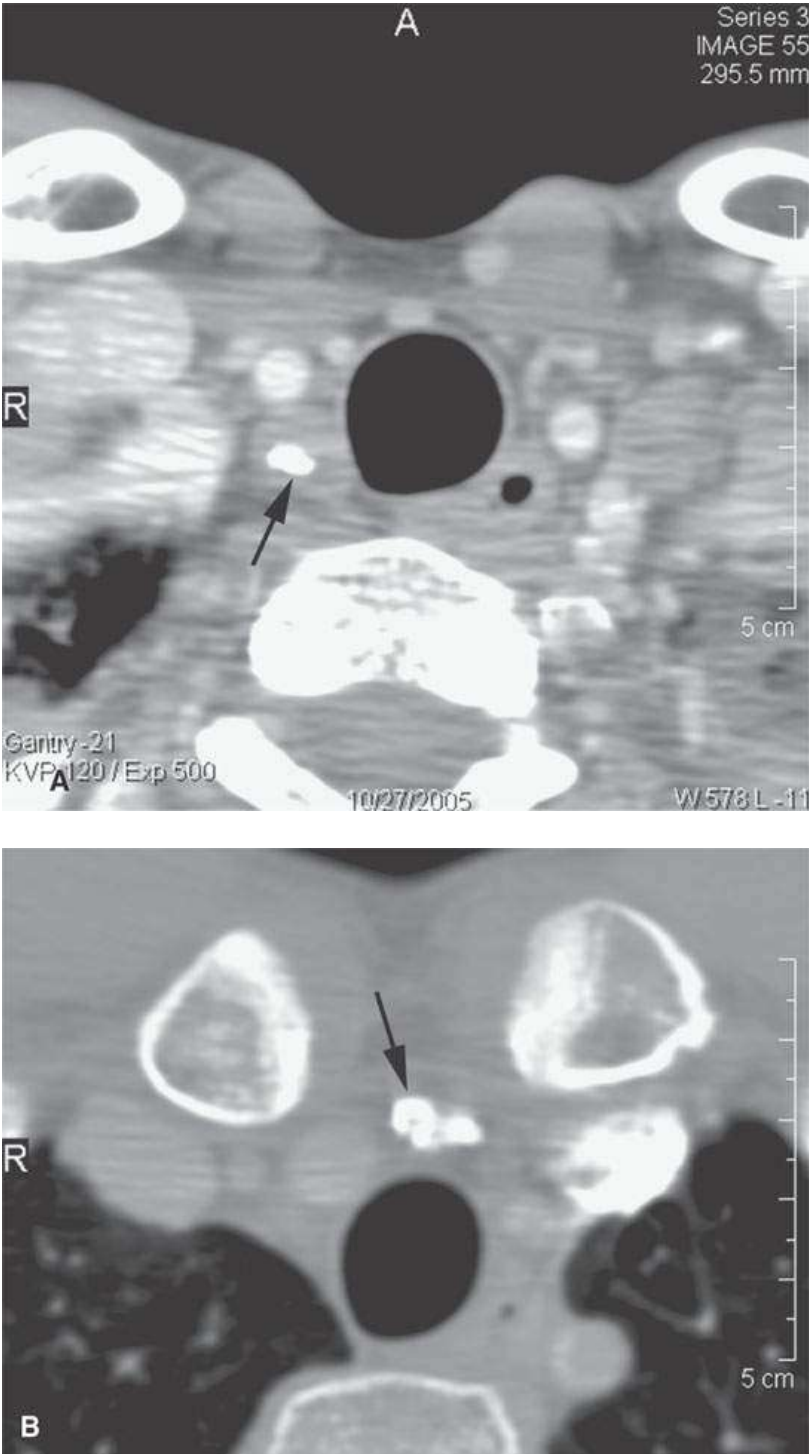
Computed tomography of dystrophically calcified level 6 nodes (*arrows*) following treatment for lymphoma.
